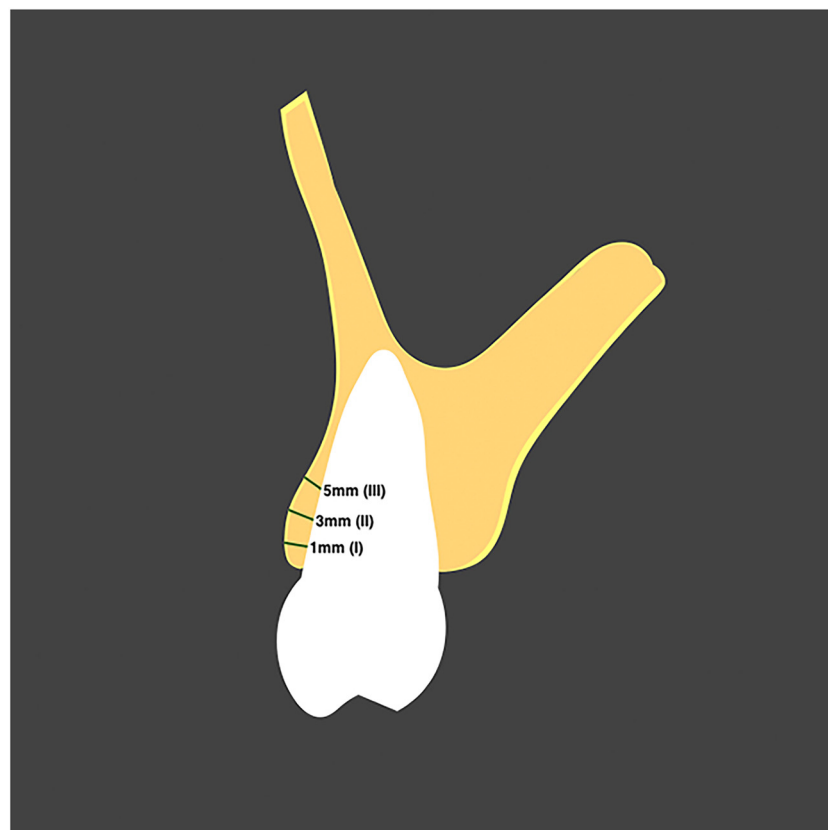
Buccal plate thickness at three locations per tooth: 1 mm (measure I), 3 mm (measure II), and 5 mm (measure III) apical to the alveolar crest. In the case of a dehiscence defect, a line was drawn from the most coronal level of the palatal/lingual plate perpendicular to its long axis and defined as the presumptive zero point for buccal-plate measurement. Cone beam computed tomography images were processed to ensure the best geometric presentation for highly accurate measurement. In the axial plane, the arch-form selector tool was centered through the middle of the arch. In the sagittal plane, the volume was oriented to enable visualization of the entire root. An individual reference line for each tooth was created to generate the ideal coronal slice at the mid-root level apicocoronally.
